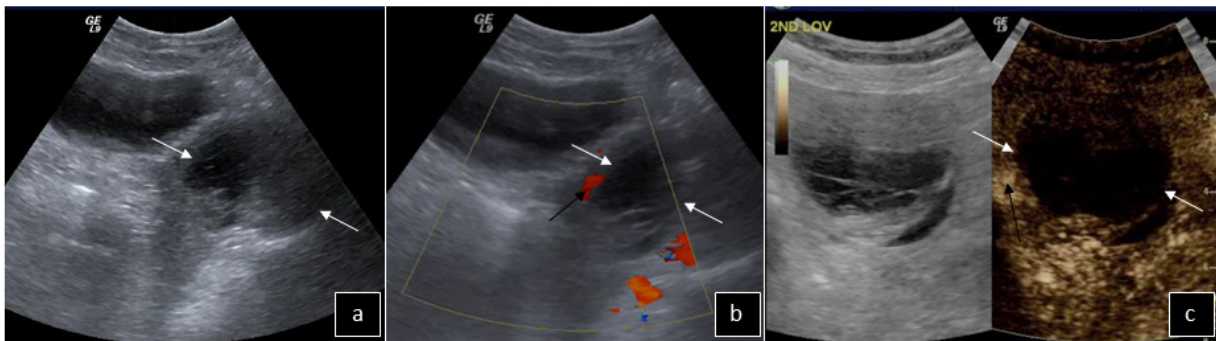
Haemorrhagic ovarian cyst: A mixed echogenicity lesion (between white arrows) is seen in the left ovary on B-mode (a) and power Doppler (b) US. Intraovarian perfusion (black arrow in b) is present. This perfusion is confirmed on CEUS (black arrow in c) but no enhancement of the cyst (between white arrows) is noted. Therefore, the lesion is not a solid mass but a haemorrhagic cyst.
